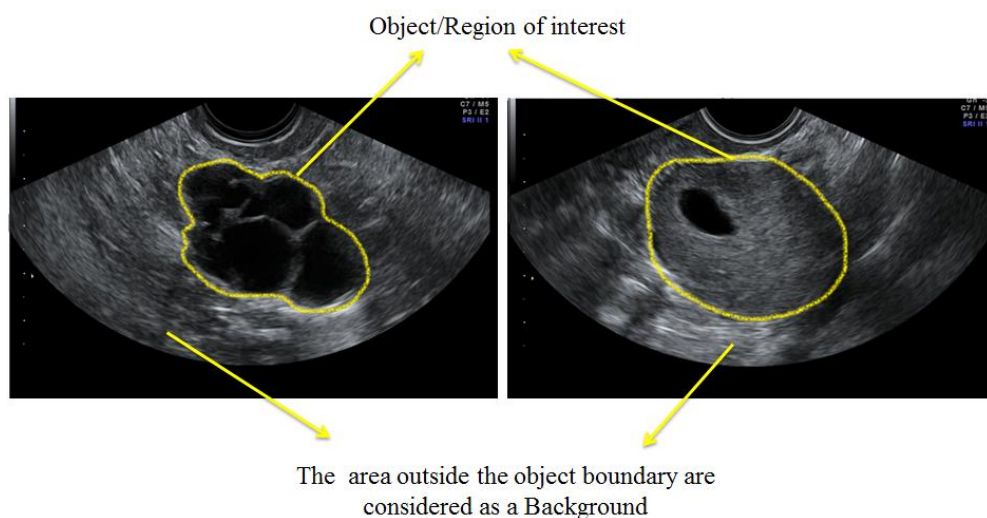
2: Ultrasound images of ovarian tumours and highlighting the ROI
